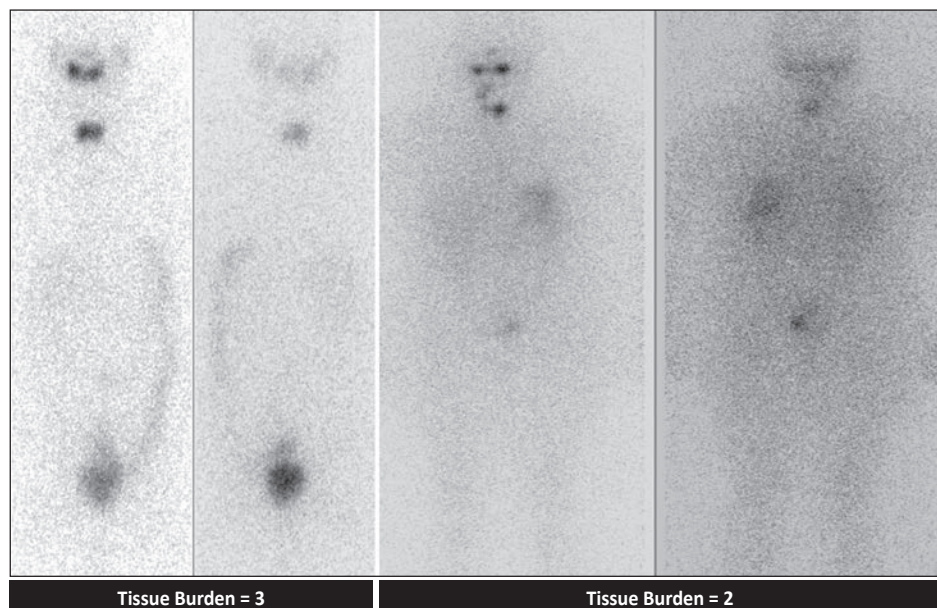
Anterior and posterior 131-I whole-body scintigraphy images showing evidence of tissue burden. The large remnant of functional thyroid tissue with intense tracer uptake presented in the left 2 panels is scored as a 3 on our visual scale. The right 2 panels display a moderately sized mass of functional thyroid tissue having a moderate intensity; its visual score is a 2.
